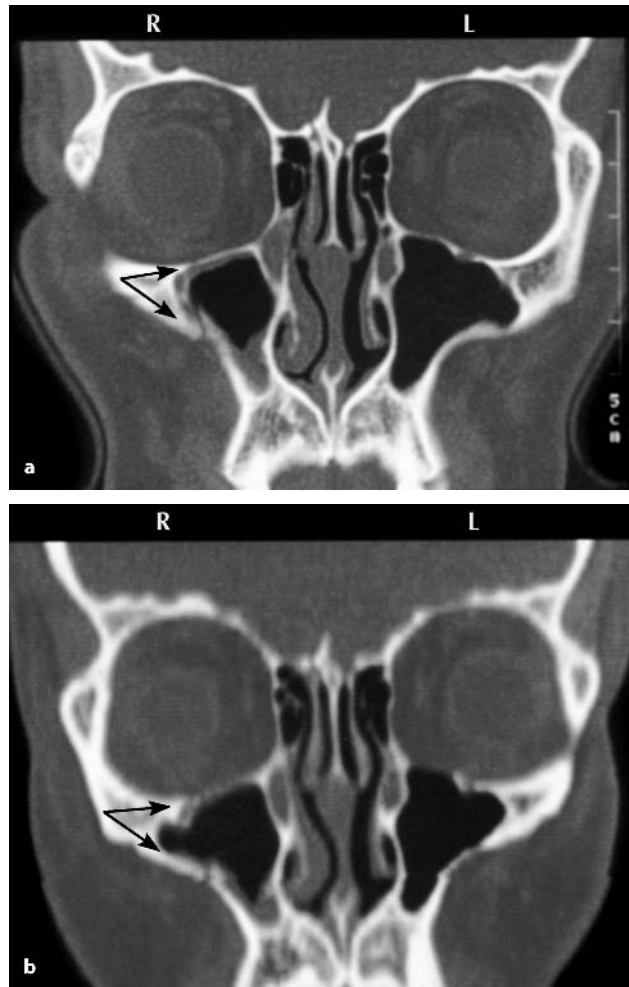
a Coronal image of the orbital bones following a fracture of the orbital floor (*arrow*) and the lateral wall of the right maxillary sinus (*arrow*): initial coronal plane with sharply defined orbital floor and good demonstration of the fracture lines. b Coronal image of the orbital bones following a fracture of the orbital floor (*arrow*) and the lateral wall of the right maxillary sinus (*arrow*): secondary reconstruction of spiral CT data with an unsharp but still recognizable image of the fracture (*arrow*)
